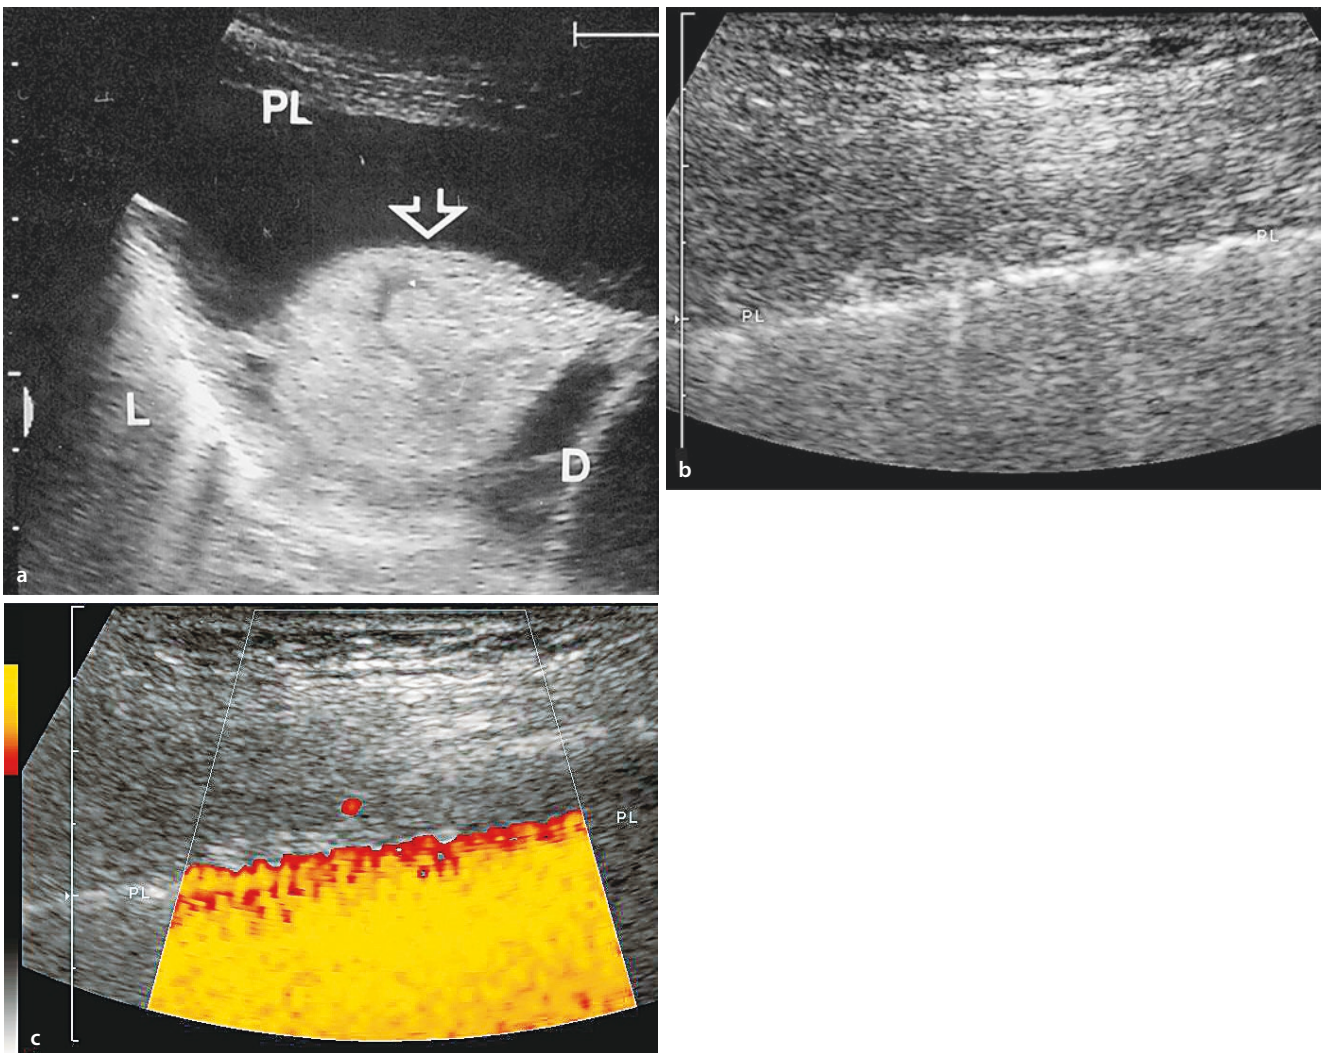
a A blood clot (*arrow*) as a complication following a diagnostic puncture of a pleural effusion. *PL* parietal pleura, *L* compressed lung, *D* diaphragm. b Pneumothorax was excluded by showing the sliding sign of the pleura. c Color-Doppler sonography in “power” mode allowed the respiration-dependent sliding sign to be
